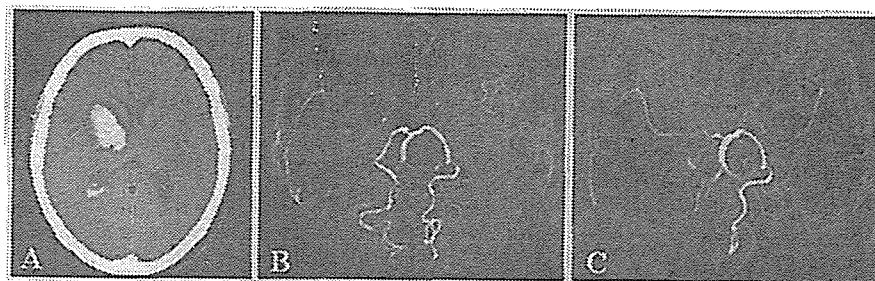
Plain computed tomography (a) and MRA (b and c) of a 56-year-old woman (case 15), showing the development of an occlusive lesion in the right posterior cerebral artery between March 2004 (b) and March 2005 (c).
